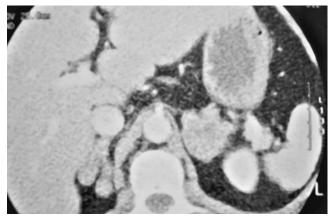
Computed tomographic scan of a 52-year-old woman with Cushing's syndrome caused by bilateral adrenal hyperplasia.
